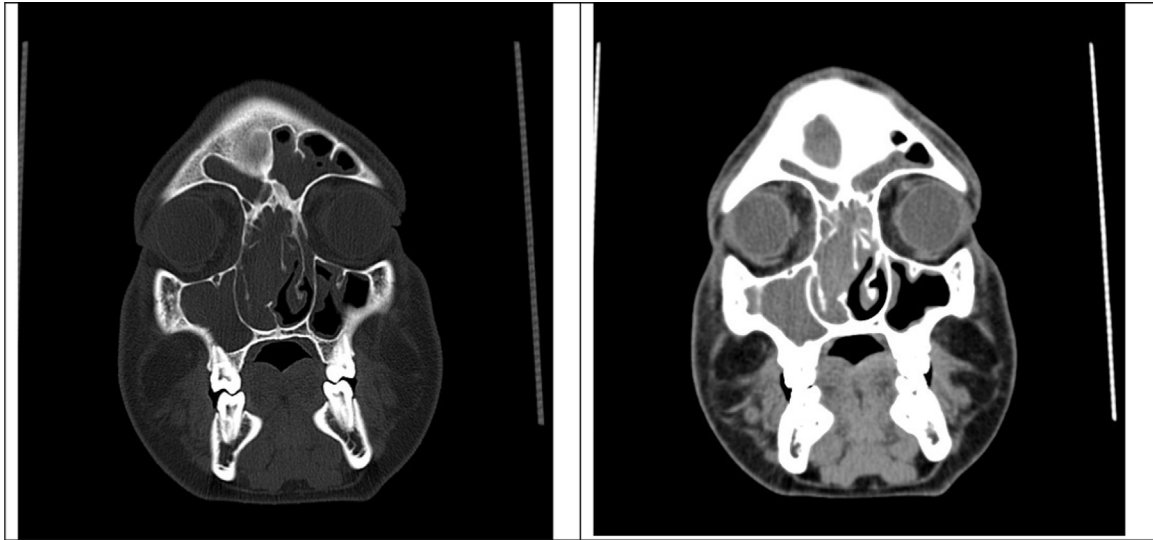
Para-nasal CT scan (PNS CT) of patient before second surgical debridement which revealed complete right maxillary sinus opacity and involvement of bilateral ethmoid sinuses without any obvious bone destruction.
